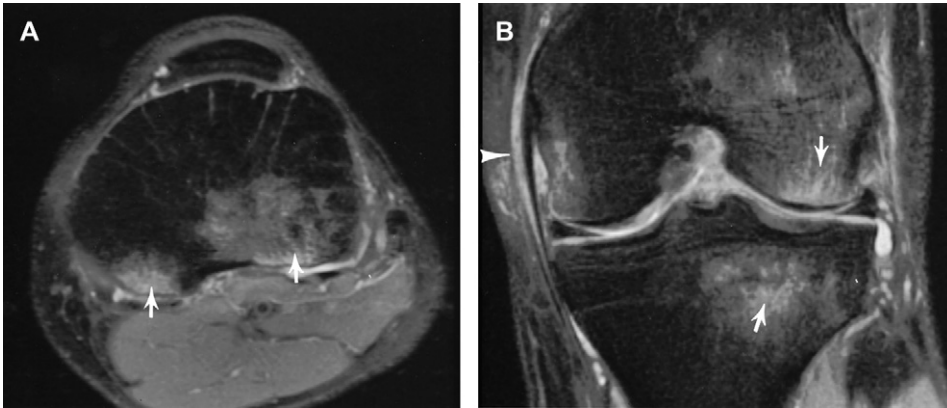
Football injury associated with valgus and rotational forces. Axial (A) and coronal (B) fat-suppressed fast spin-echo T2-weighted images demonstrate posterior tibial bone bruises (arrows in A) with lateral femoral and tibial bruises (arrows in B) caused by valgus stress. The increased signal intensity in the medial collateral ligament (arrowhead) is caused by ligament sprain. The anterior cruciate ligament is also torn.
